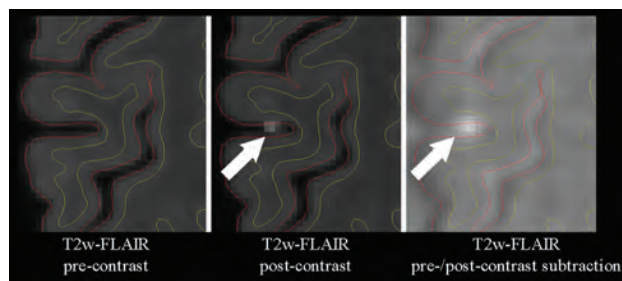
A representative case depicting the T2WI FLAIR precontrast, T2WI FLAIR postcontrast, and T2WI FLAIR pre-/postcontrast subtraction images. The FreeSurfer-derived white and pial surfaces are shown in yellow and red, respectively. The *white arrow* shows a focus of leptomeningeal contrast enhancement.
